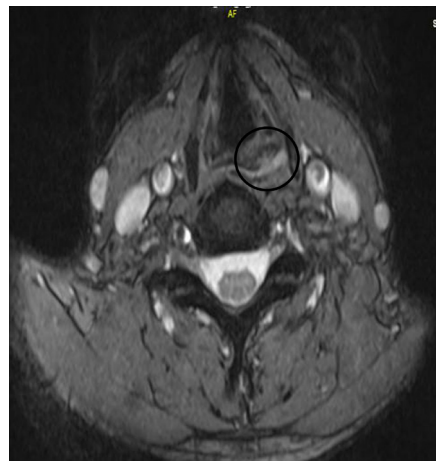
Axial T2-weighted MRI image showing paraesophageal edema (in circle).
